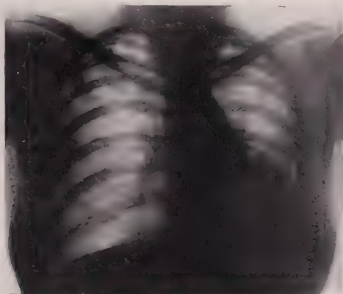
Roentgenogram made on August 28, 1946, on admission, showing minimal tuberculous process in the extreme apex of each lung but no evidence of recent infiltration. The left lower lobe is dense and shrunken in size. The heart is displaced to the left.
